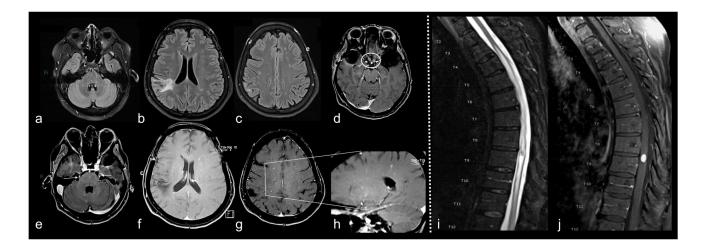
Radiological features in patients with CNS toxicities. (a-h)Brain MRI of patient #25 with cerebral angiitis: axial FLAIR (a-c)and post contrast T1-weighted images, axial (d-g) and sagittal (h). Multiple punctate foci of T2 hyperintensity are evident in the pons (a) and in the subcortical white matter bilaterally (b,c), with a previous known encephalomacic area in the right temporo-parietal junction (b). Numerous punctate areas of enhancement are documented post-gadolinium injection, both infra (e) and supratentorially (f,g)
